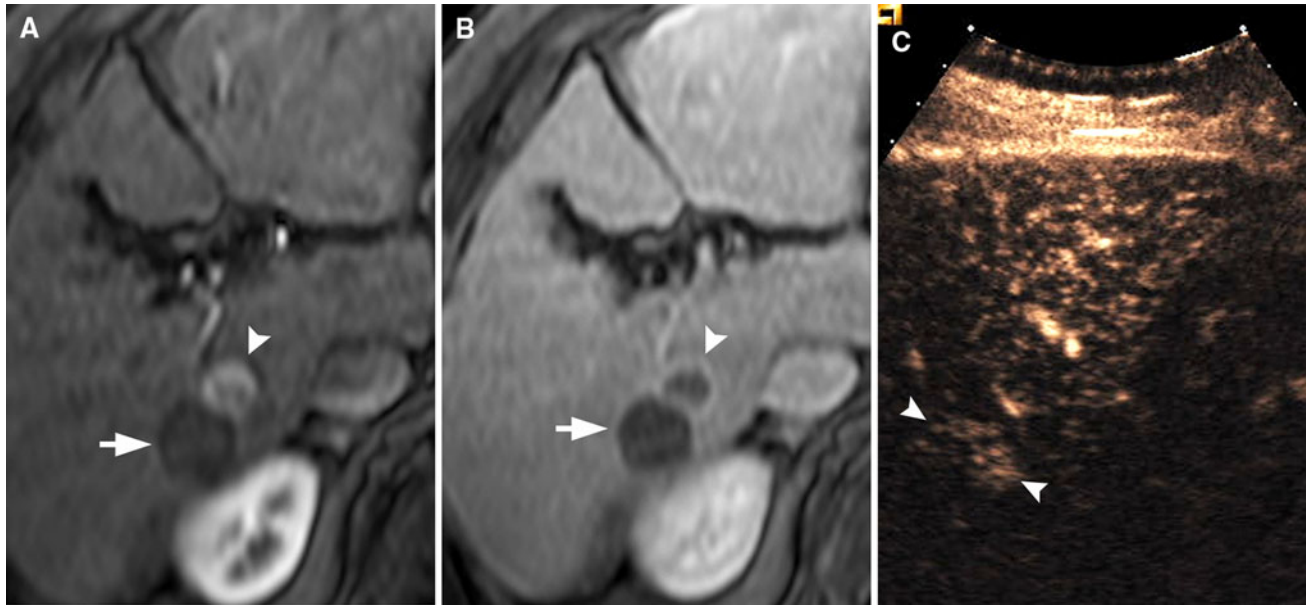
Recurrence of HCC with nodular pattern. Enhanced images on MRI on arterial (A) and delayed phases (B) show a necrotic lesion in the right hepatic lobe (*arrow*) and nodular arterial enhancement in the periphery of the lesion with an
